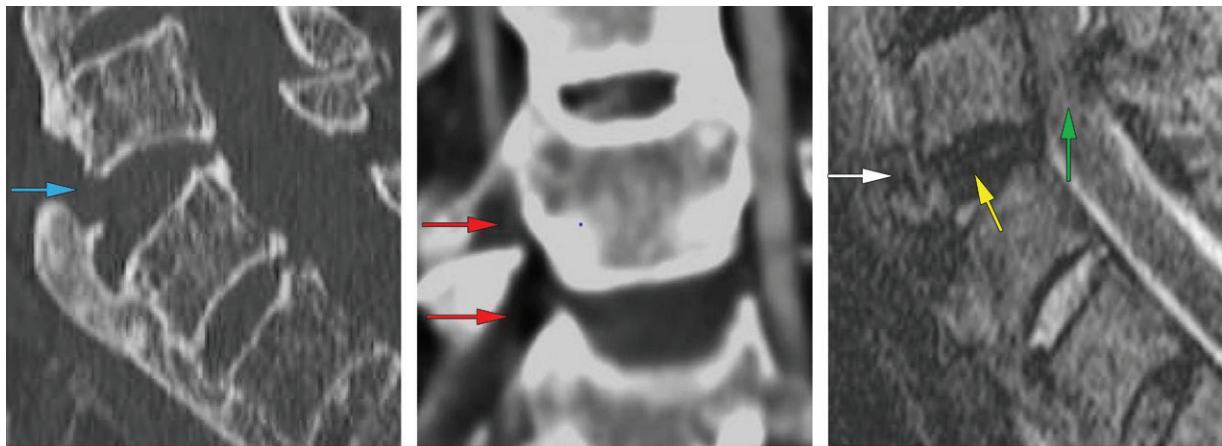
Acute vertebral artery dissection in a 75-year-old man with DISH and a recent history of falls who presented with right upper extremity weakness. (a) Sagittal CT image shows DISH, with asymmetric anterior disk space widening at C4-5 and discontinuity of the anterior fused mass, a finding representing a hyperextension injury (arrow). (b) Coronal CT angiogram shows narrowing of the right vertebral artery (arrows), a finding that represents acute dissection. (c) Sagittal T2-weighted MR image shows anterior disruption (white arrow), disk rupture (yellow arrow), and severe canal stenosis with some spinal cord edema (green arrow).
